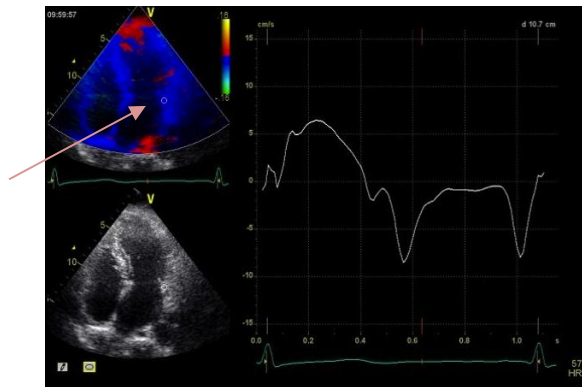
3D/4D echocardiograph with tissue velocity curve (right) that correlates with the point circled in white on the top-left graph pointed by the arrow. These data are obtained from GE Vivid 7 scanner. The colour blue refers to the blood flow being away from the receiver whilst the red colour towards the transducer.
